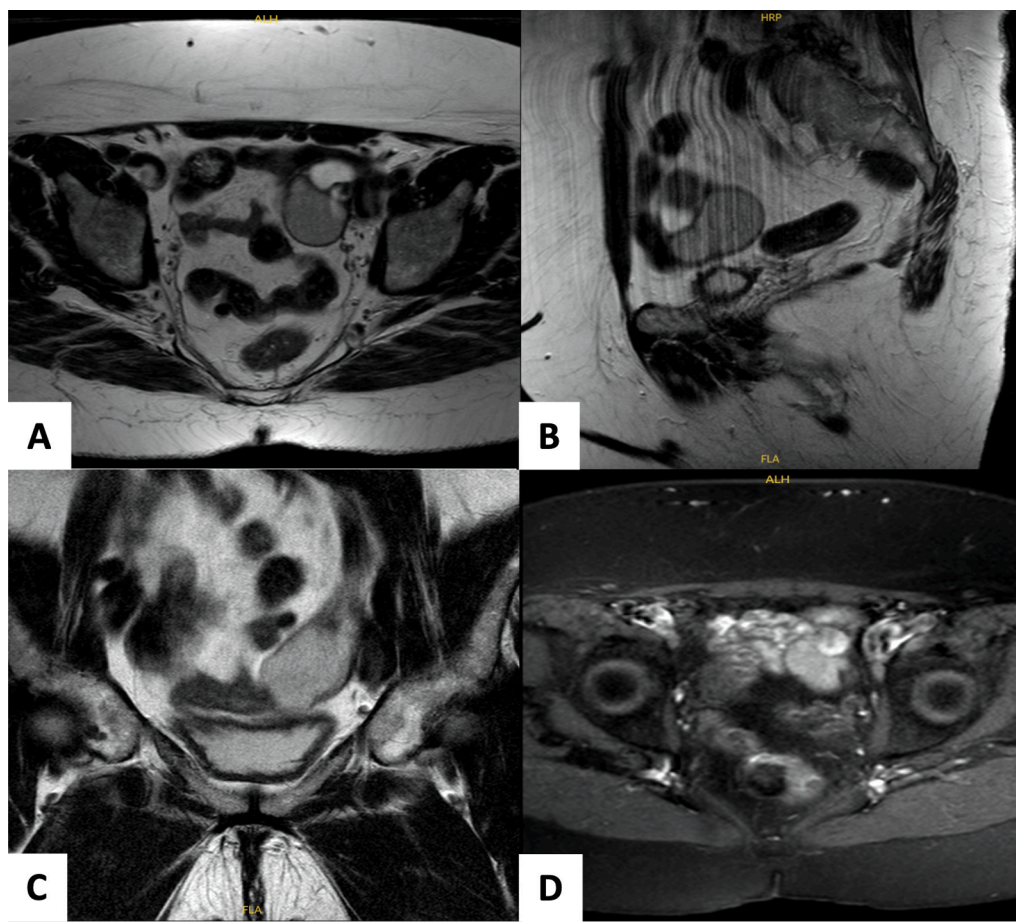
A) MRI Pelvis Axial T2 TSE image of mass; B) MRI Pelvis Sagittal T2 TSE image of mass; c) MRI Pelvis Coronal T2 TSE Sense image of mass; D) MRI Pelvis Axial FS T1 image of mass.
